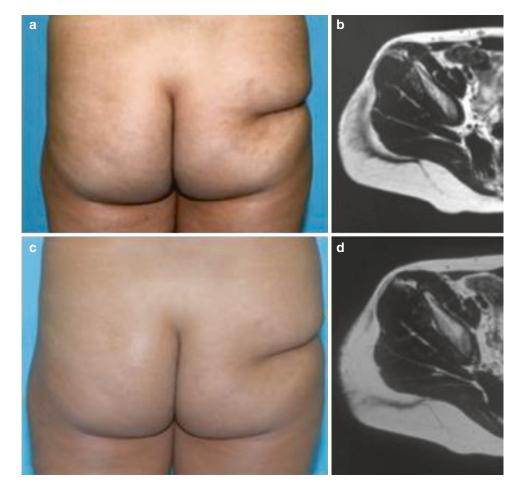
(a–d) Gluteal withdrawal without cutaneous lesion as an example of subdermal scar formation after a hematoma of the soft tissue. The MRI proves the beginning of the scar dissolution after the first procedure
